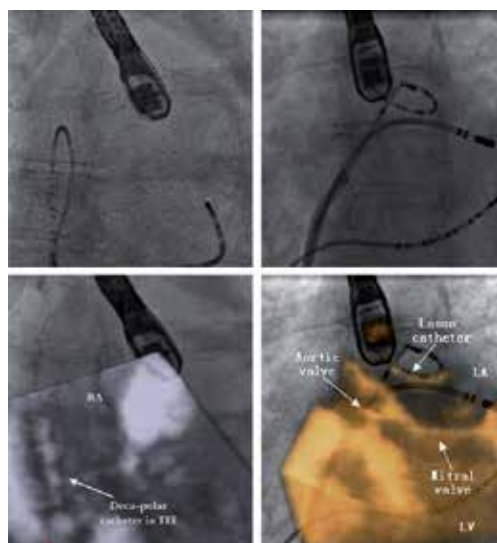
(First column) the TEE volume shows a deca-polar catheter positioned in right atrium and dots highlight the position of the deca-polar catheter in the background of the X-ray image. (Second column), a lasso catheter was inserted into the left atrium with TEE volumes registered to X-ray images. Image taken from King et al., 2010.
